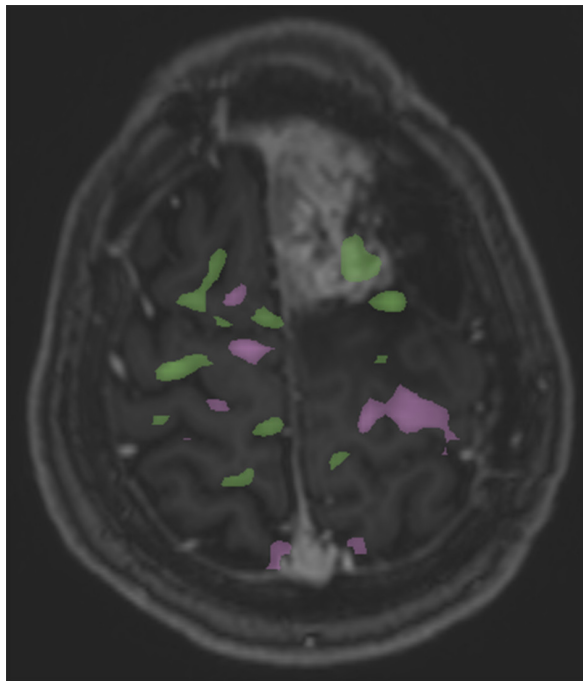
Functional magnetic resonance image of the hand motor task showed cortical activation in the middle part of left precentral gyrus (purple colour).
